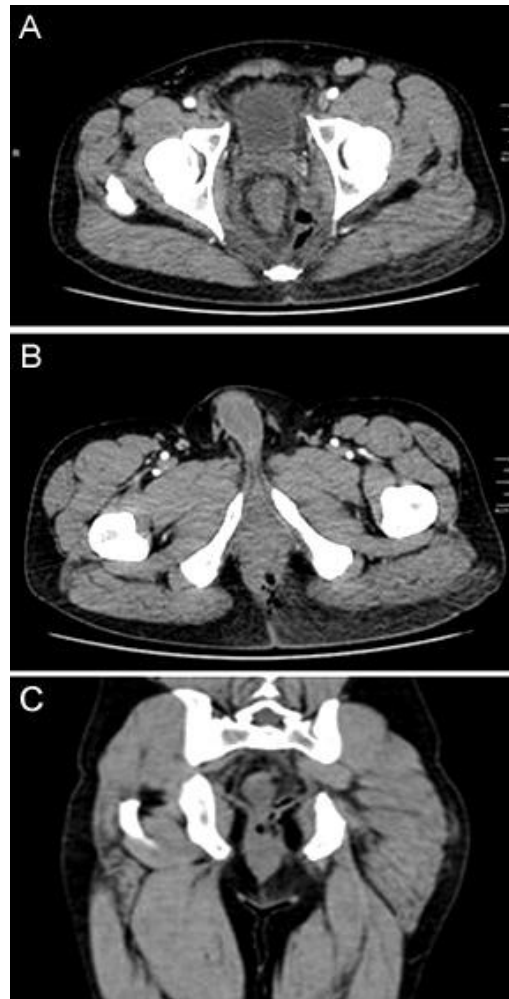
Pelvic CT scan. Axial sections showing left anorectal injury. A. Perirectal air bubbles. B. Defect of the left sphincter complex with perianal air bubbles. C. Coronal section with air bubbles in the left mesorectum of the inferior rectus.
